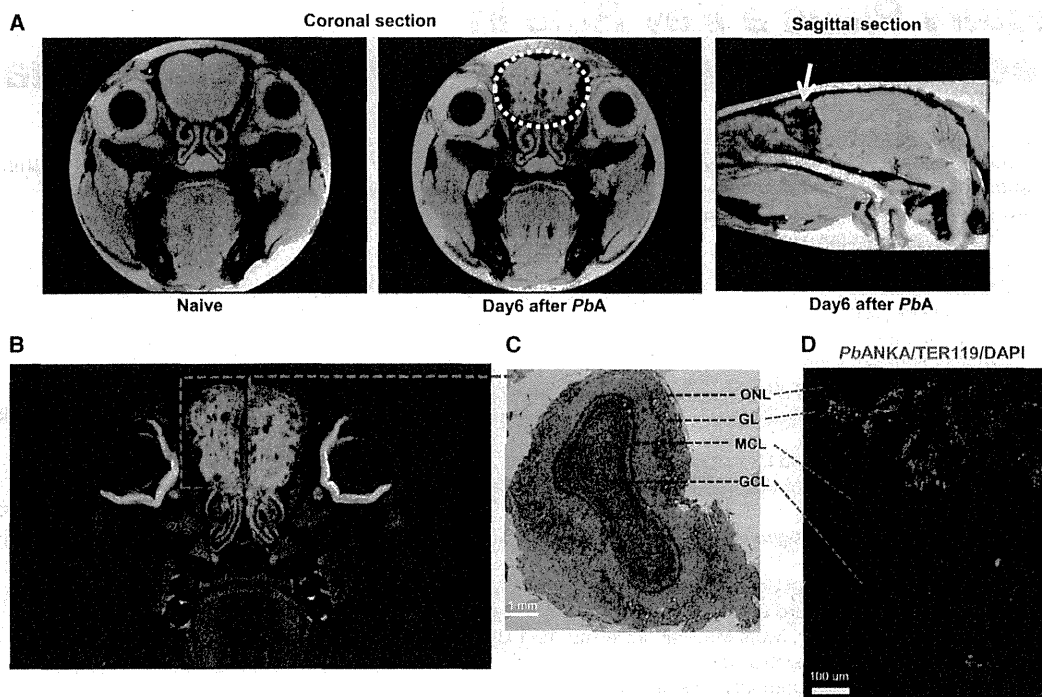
Ultra-High-Field MRI Identifies OLF Bulb as a Vulnerable Location for *PbA* Parasites
